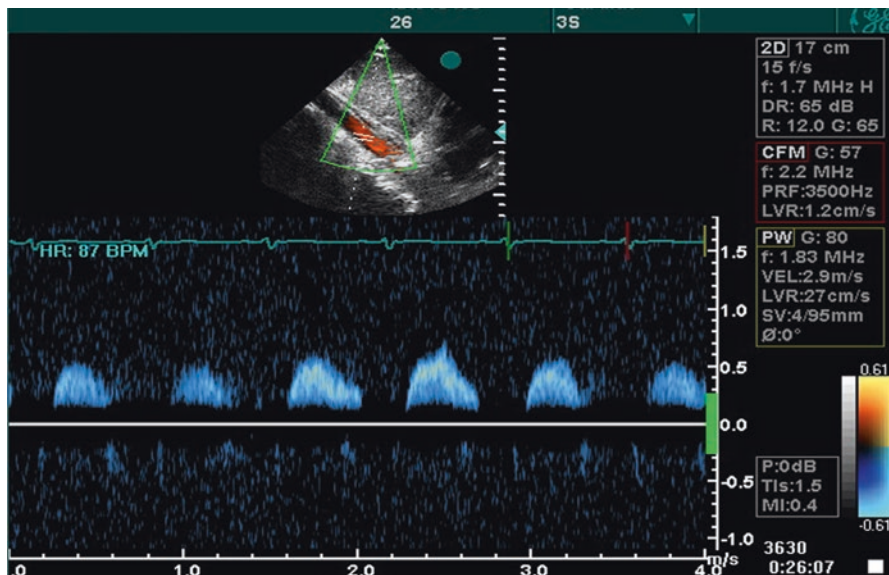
Typical Doppler flow for aortic coarctation of abdominal aorta
